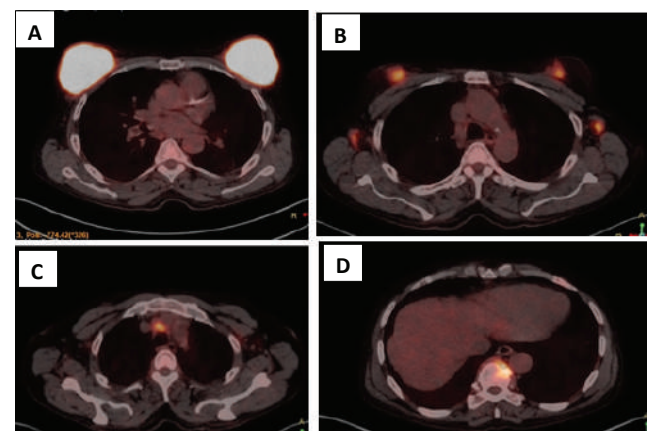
^{18}F -FDG PET-CT fused axial images in a 70-year-old male showed bilateral breast enlargement with intensely hypermetabolic soft tissue masses in both breasts (A). Hypermetabolic lymph nodes in axilla (B), mediastinum (C) and skeletal (D) involvement.
